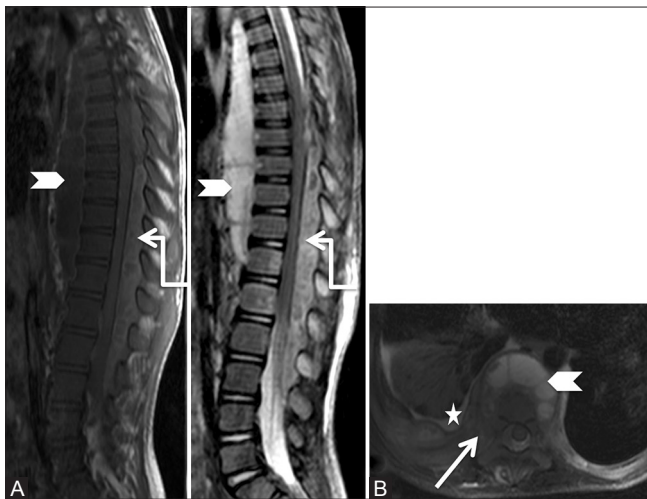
(A and B): Infective: Tuberculosis: 7-year-old boy with paraparesis. Sagittal T1-weighted (A) and T2-weighted (B) images of spine showing large posterior epidural abscess (elbow arrow) extending from T6 to L3 levels, compressing the cord anteriorly. Also note large prevertebral soft tissue (arrowhead). On axial T2 fat-saturated images, involvement of right costovertebral and costovertebral junction and adjacent rib (arrow) is seen. Minimal right pleural effusion is seen (star)
